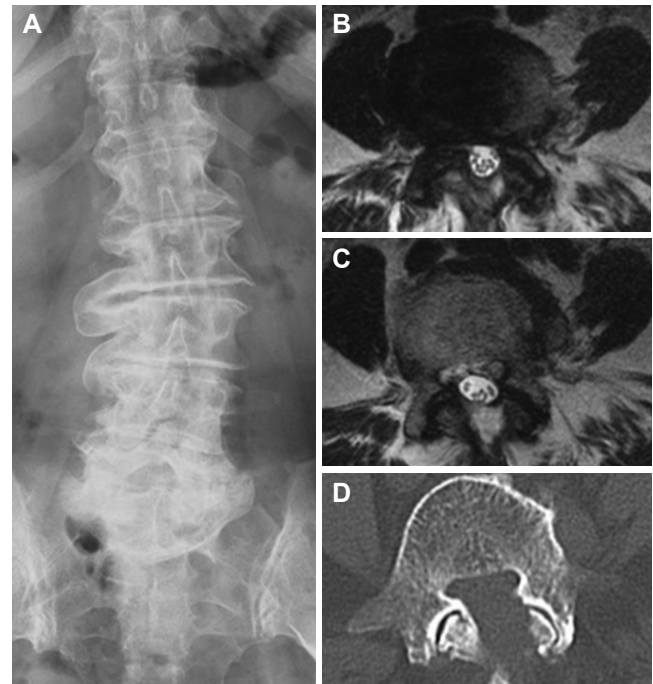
Preoperative neuroimages reveal degenerative lumbar scoliosis and remarkable bilateral canal stenosis with hypertrophied ligamentum flavum and superior facet joint at L4/5. A: Roentgram (A-P); B, C: magnetic resonance imaging T2WI axial image at L4/5; D: computed tomography axial image at L4/5
